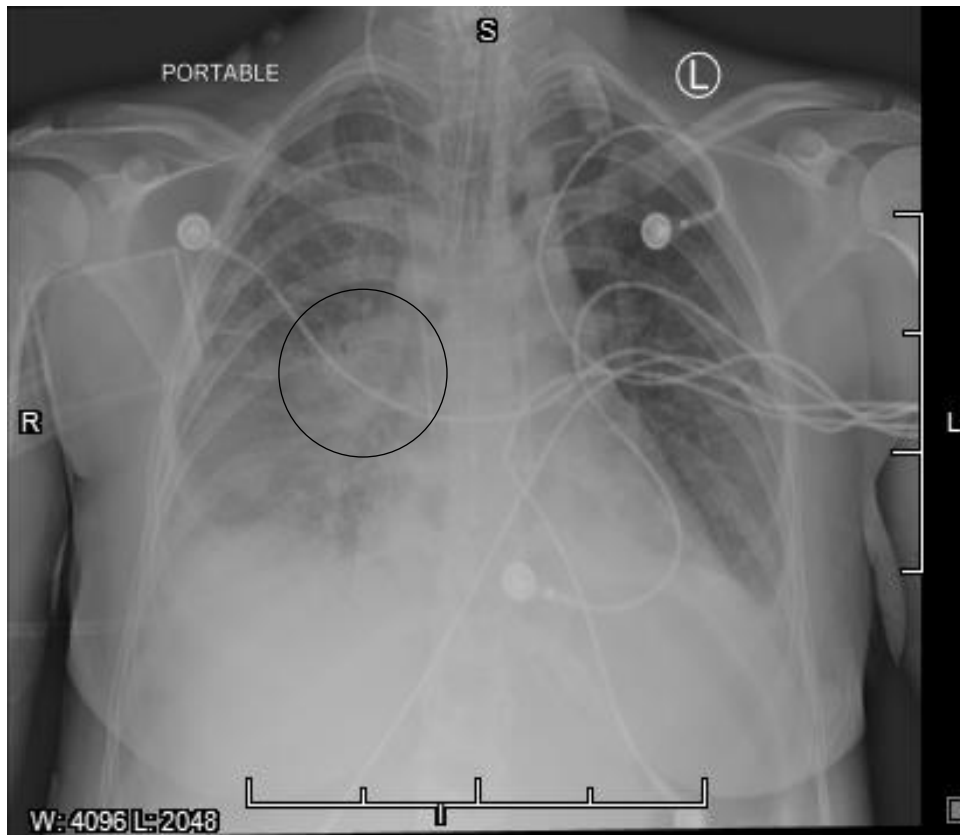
Chest radiograph showing right mid and lower lung infiltrates with right pleural effusion. Palla's sign is seen in the circle. Ancillary findings include endotracheal tube and central venous catheter appropriately placed.
